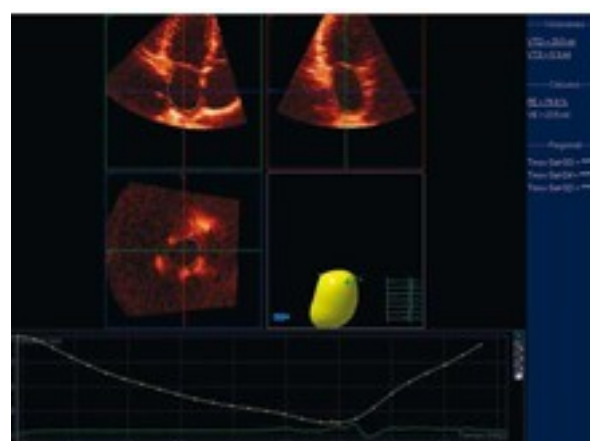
Measurement of left atrial volume using real-time three-dimensional echocardiography
